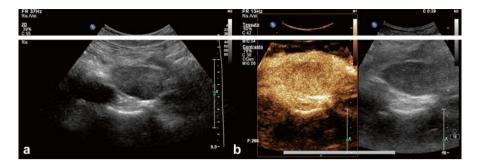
(a) Transabdominal ultrasound: hypoechoic, well-defined, homogeneous, pancreatic NET. (b) At CEUS the lesion shows enhancement in the arterial phase (29 s after injection of SonoVue)
